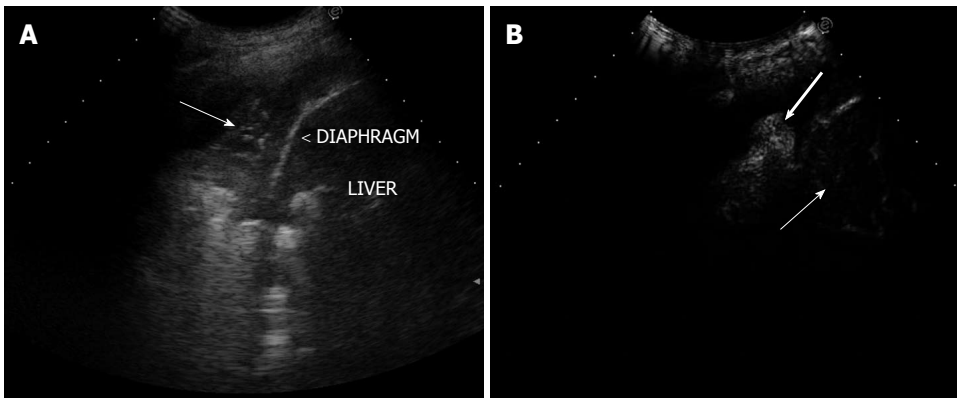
Early arterial enhancement. A: Transverse sonogram showing parenchymal consolidation of the lower lobe of the right lung (arrow); B: Transverse contrast-enhanced sonogram in the arterial phase showing clear enhancement of the lung consolidation (large arrow); the enhancement of the liver is still starting (thin arrow). Final diagnosis was slow resolution pneumonia.
